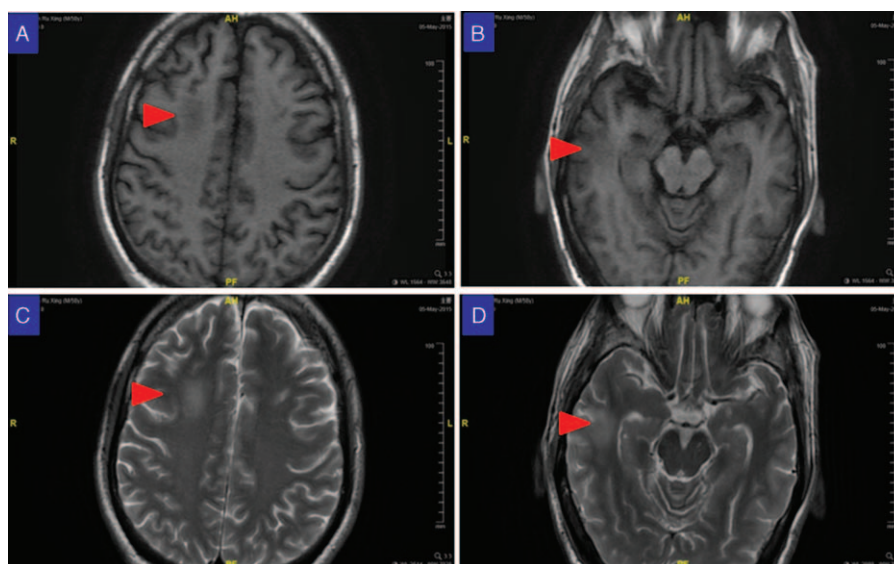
Axial T1 (A, B) and Axial T2 (C, D) weighted MR images on the 14th day after administration of methylprednisolone: the lesions are significantly smaller compared with Fig. 1. MR = magnetic resonance.
